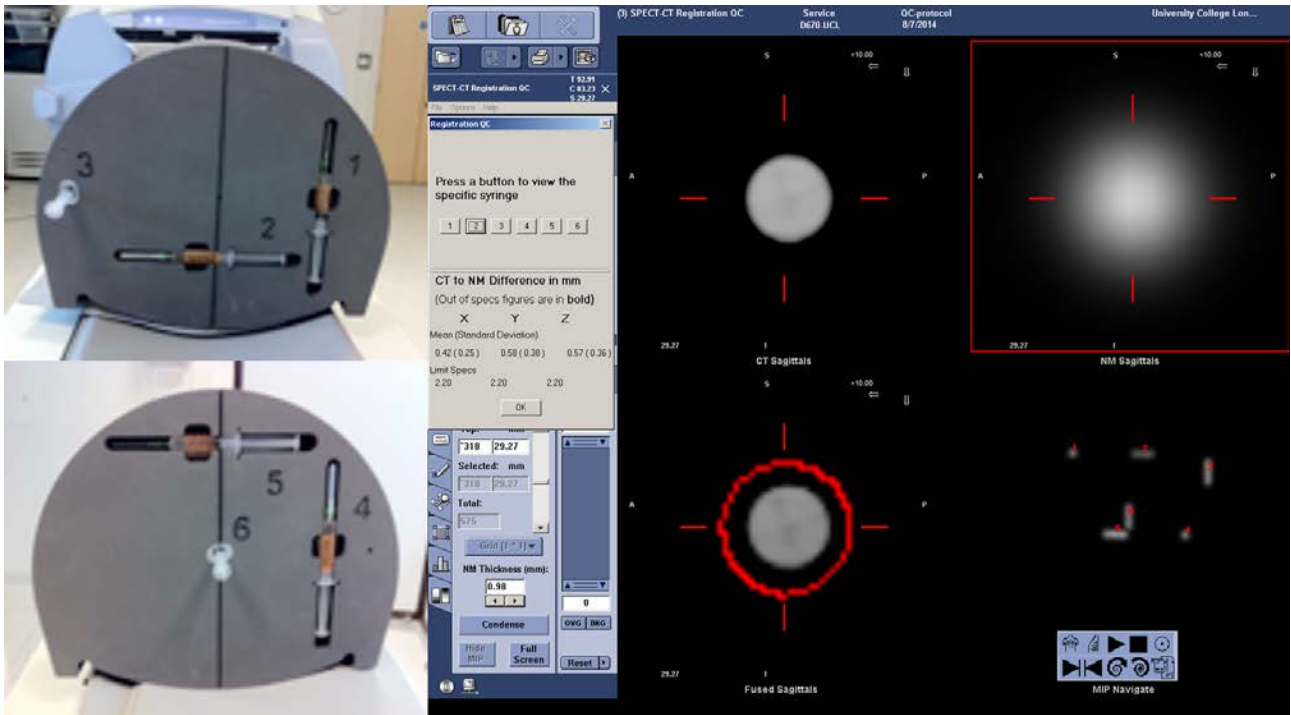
SPECT/CT registration tool (left) from a manufacturer, which includes six line sources seen in the SPECT and CT images (right).
